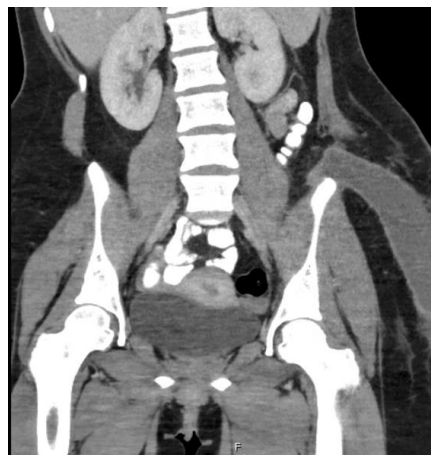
A coronal view of a CT image showing a persistent left parailiac flank hernia with a complex, enhancing fluid collection measuring $17.1 \times 10.9 \times 5.2$ cm, concerning for an abscess or infected hematoma.
